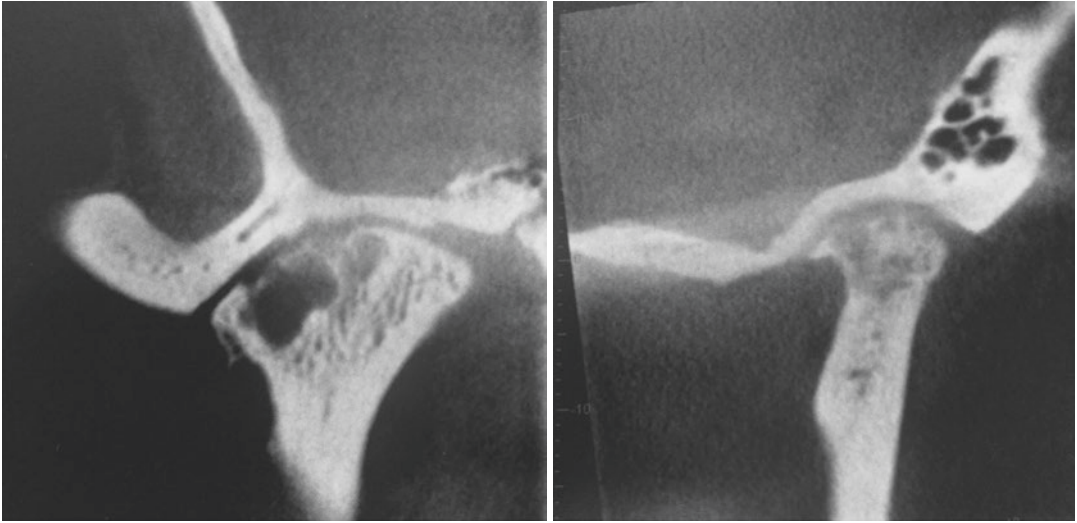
Category 5 Catastrophic TMJ Changes—Cone beam CT scan showing large sub-chondral cyst in the roughened condylar head which is typical of severe degenerative joint disease in which the joint cannot be salvaged
